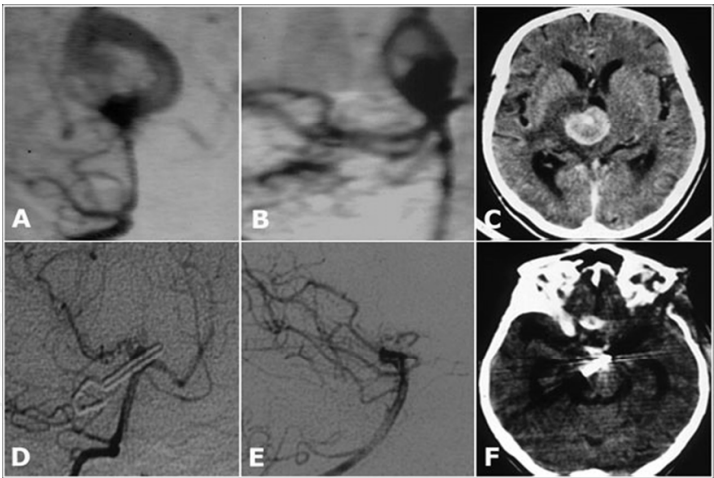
Preoperative angiography (A,B), preoperative CT scan (C), postoperative angiography (D,E) and postoperative CT scan (F) of a giant basilar tip aneurysm, located high with respect to the posterior biclinoidal line, embedded into the third ventricular room, exposed through a fronto-temporo-orbito-zygomatic approach.
